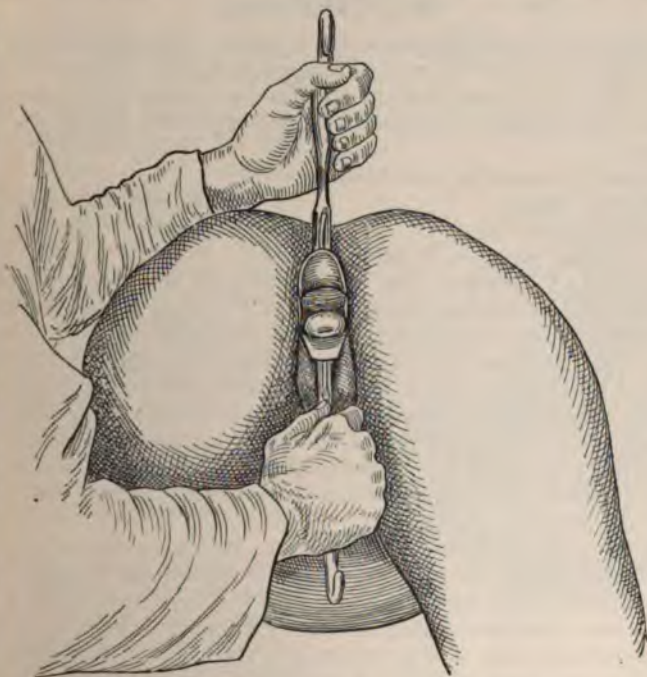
INDIRECT INSPECTION OF THE VAGINA (page 238).
